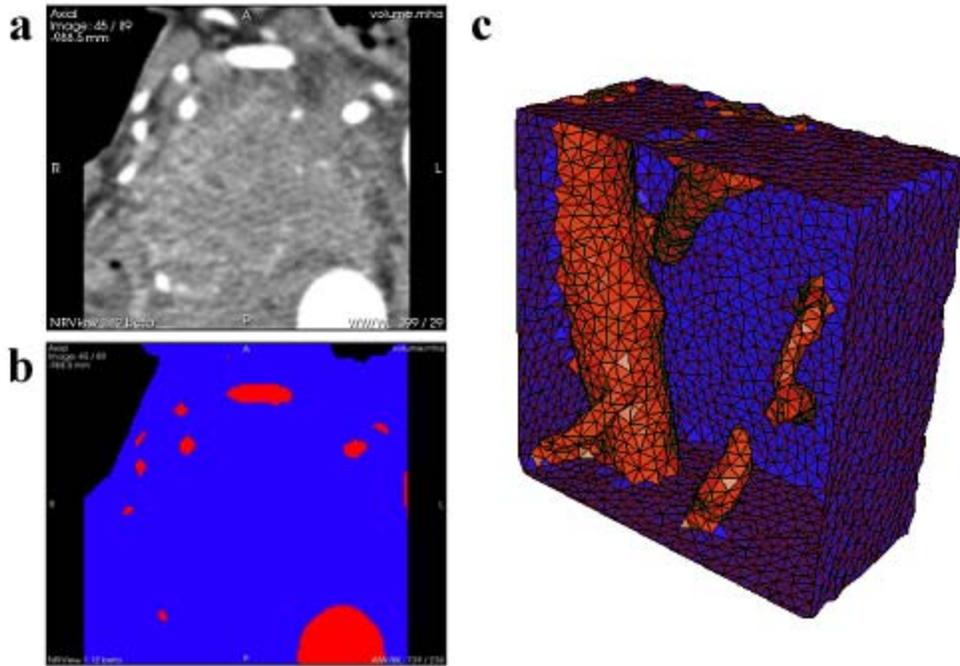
(a) A single axial DICOM slice of the pancreas and surrounding tissue is shown from the pre-treatment contrast CT scans. Bright areas are indicative of contrast enhanced major blood vessels, while the dark areas in the top left and top right are air. (b) Segmentation of the same axial slice into different regions based on tissue type: blue is pancreatic or surrounding tissue, red is blood vessels, and black is air. (c) Rendering of a 3D tetrahedral mesh of the pancreas and surrounding tissue in blue, and blood vessels in red. It is clipped by a plane to visualize the interior of the mesh.
